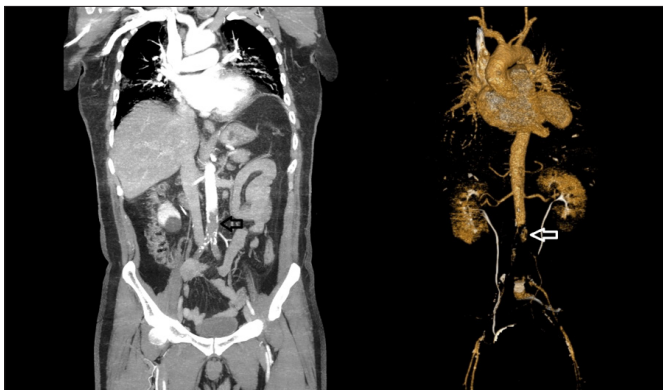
Infra-renal distal aortic and left iliac artery thrombotic occlusion on CT angiography, 3-dimensional reconstruction (arrows).
